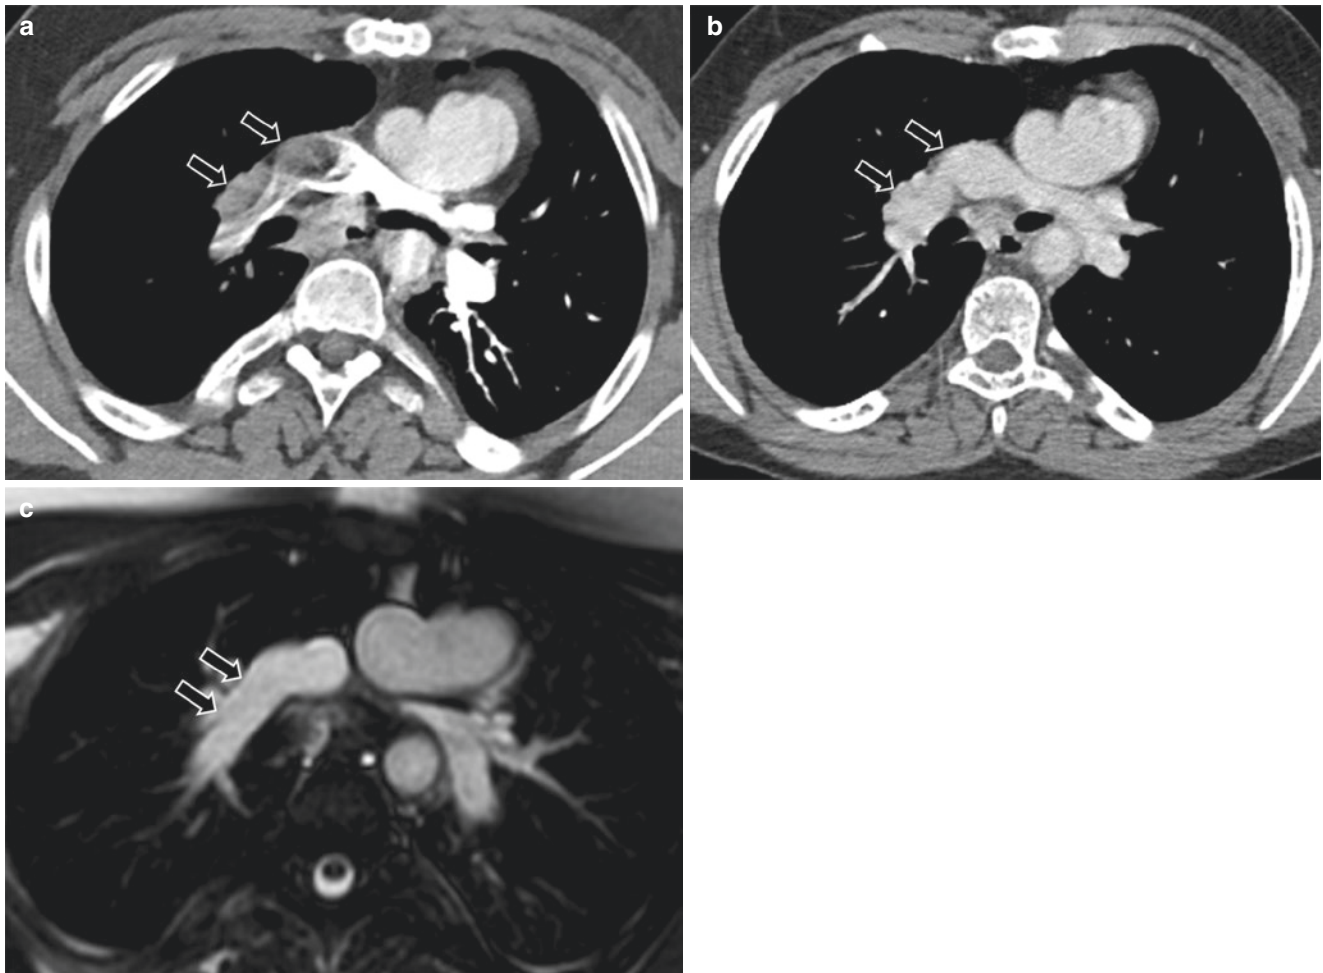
A 14-year-old girl with Fontan with indeterminate CTPA study. (a) CTPA demonstrates suboptimal pulmonary arterial enhancement and apparent filling defects (arrows) in the right main pulmonary artery, which are indeterminate and may reflect pulmonary emboli and/or slow flow with mixing artifact in the Fontan pathway. (b) Delayed CT images demonstrate resolution of previously seen apparent filling
